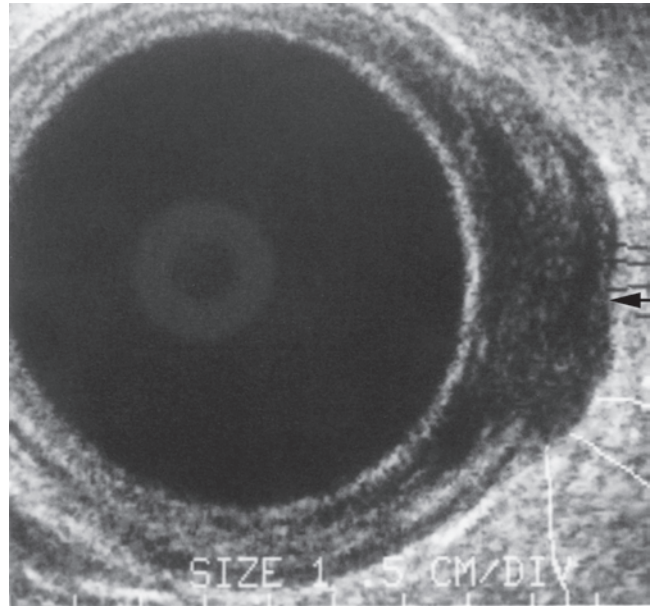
Transrectal endoluminal ultrasonography of a uT2 lesion. The arrow indicates the intact serosa.
